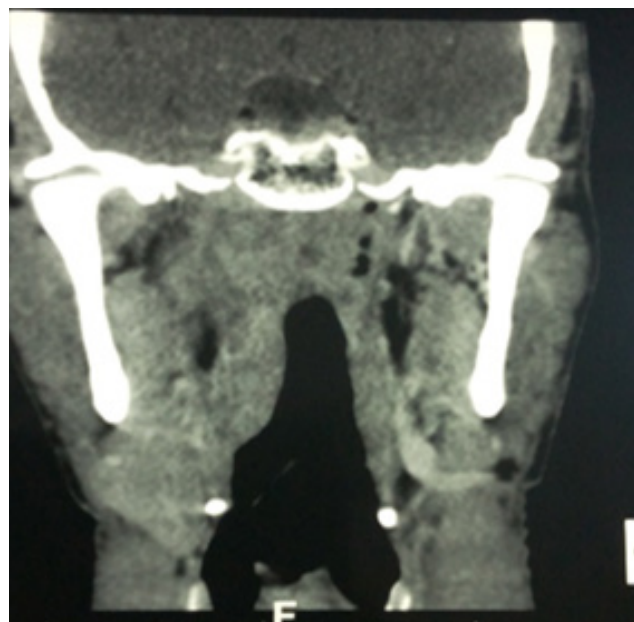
coronal CT scan image showing soft tissue mass of the right lateral pharyngeal wall
